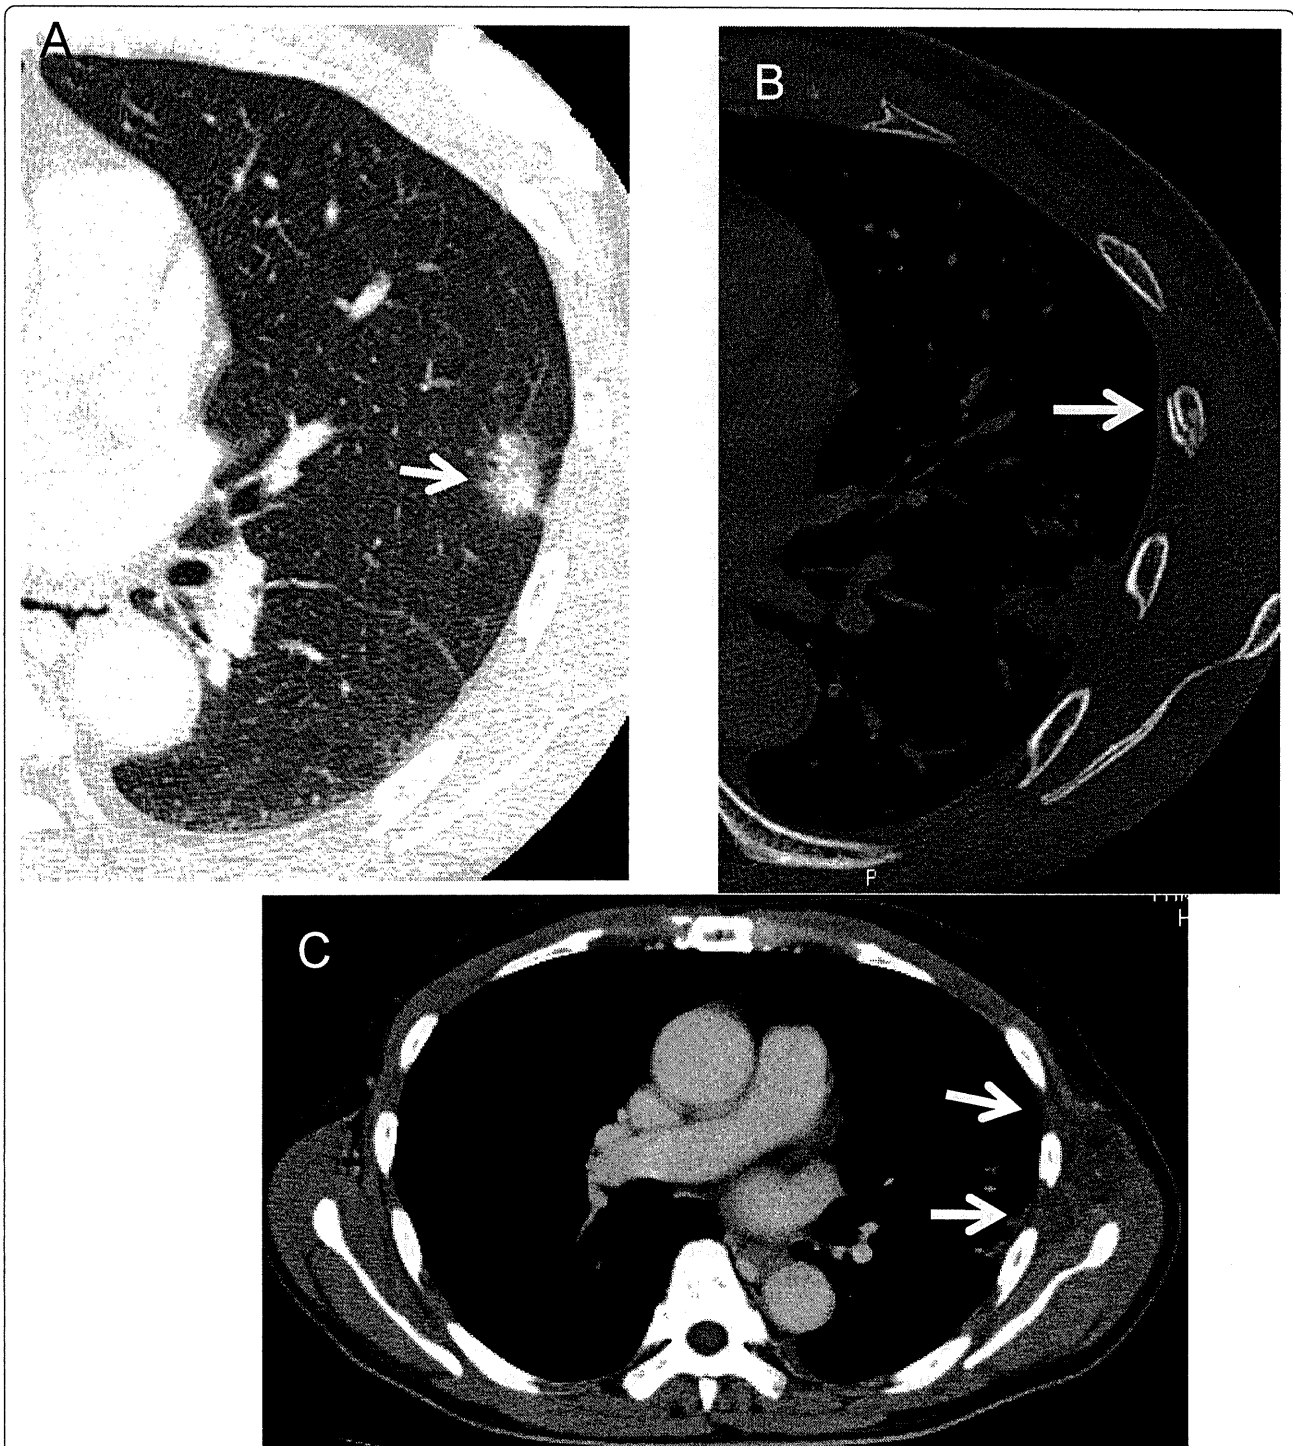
A 65-year-old man with a rib fracture after SRT. A, Preradiotherapeutic thin-section CT showing a spiculated nodule with surrounding ground-glass opacity close to the chest wall (arrow). B, Twelve months later after SRT, a rib fracture is apparent (arrow). C, At 6 months after SRT, enhanced CT shows swelling of the left chest wall with an area of low attenuation (arrows).
